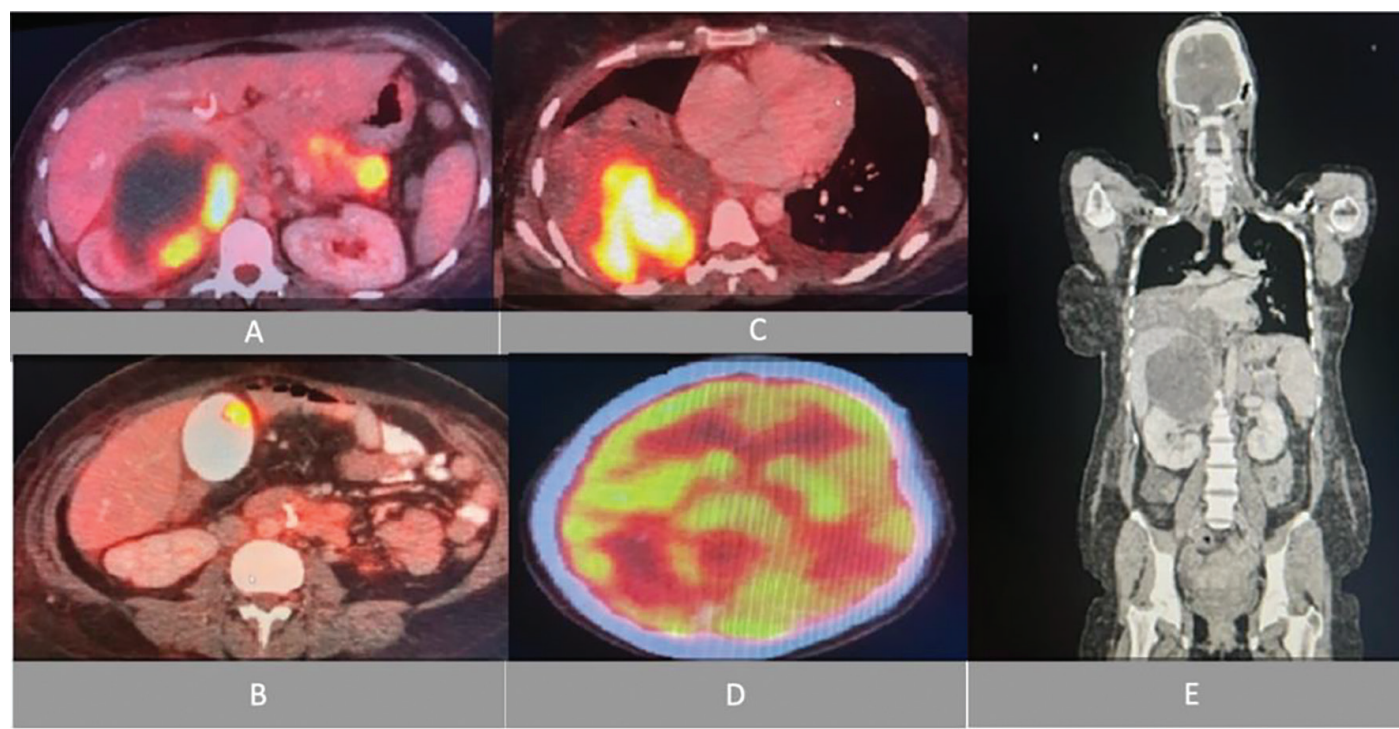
Positron emission tomography-computed tomography findings. (A) Increased FDG uptake in the right adrenal gland. (B) Distended gallbladder with contrast enhancement. (C) Increased FDG uptake in the basal segment of the lower lobe of the right lung. (D) Multiple metastatic deposits in the brain. (E) Coronal view showing widespread metastases
